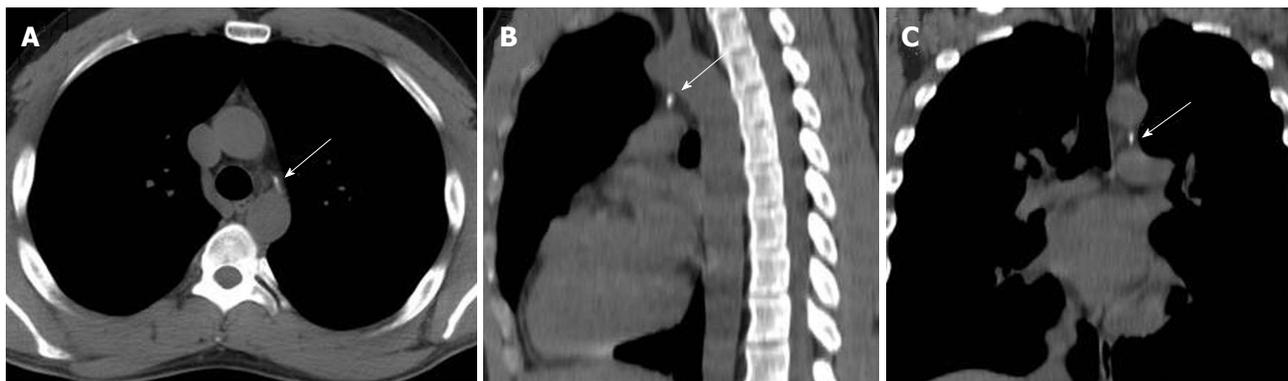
Non-contrast computed tomography in another patient. A 30-year-old asymptomatic man. Axial (A), coronal (B) and sagittal (C), reformatted images demonstrating the course of the calcified ligament arteriosum (arrows).
